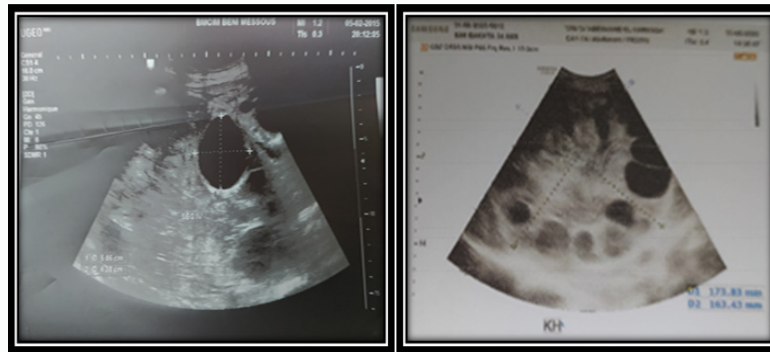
Abdominal ultrasound showing giant hepatic cyst.
